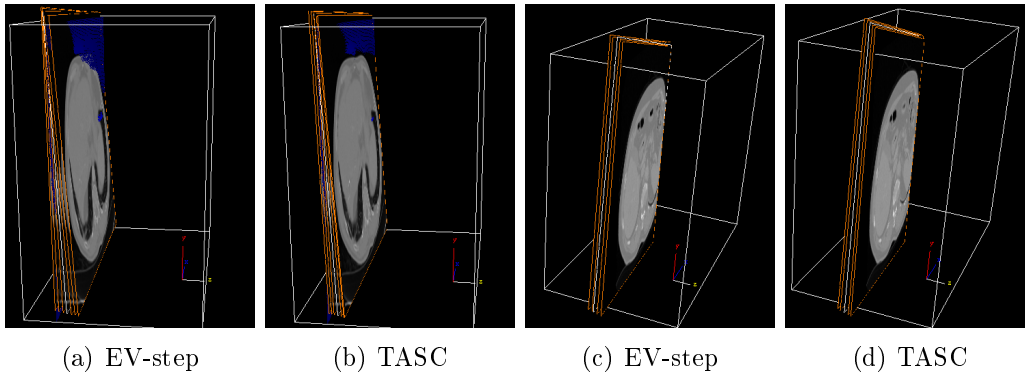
3D views of estimated slices for synthetic data – results for the TASC algorithm. (a) and (b) show results for synthetic CT-fluoro slices including noise and deformations. (c) and (d) show results on clinical CT-fluoro data.
